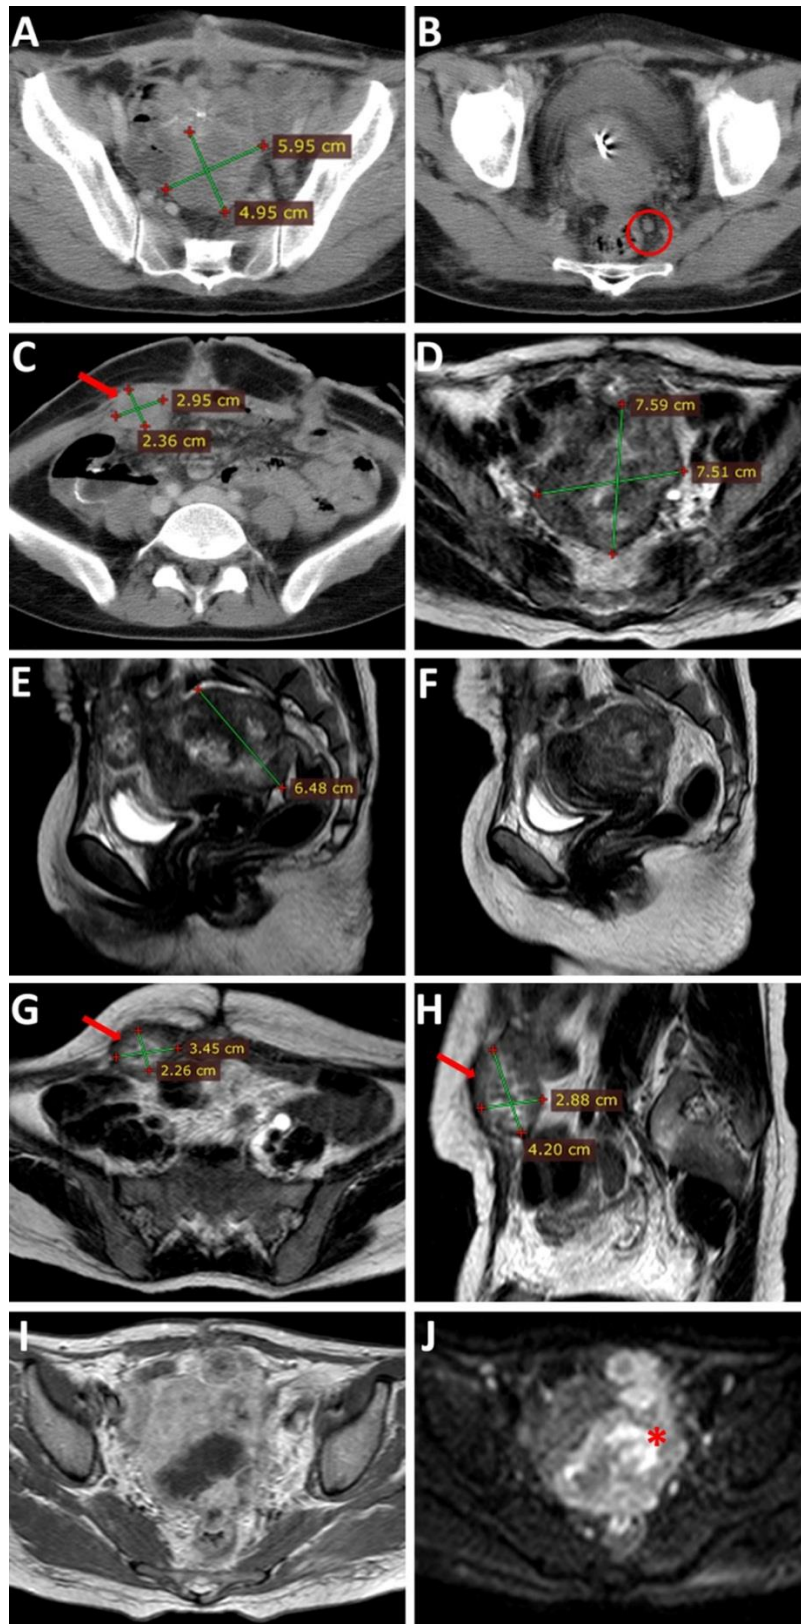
Case (2), (A, B & C) axial post contrast CT, (D,E& F) Axial & Sagittal T2WI, (G& H) T2WI at higher level, (I) axial T1WI post-contrast, (J) DWI.
